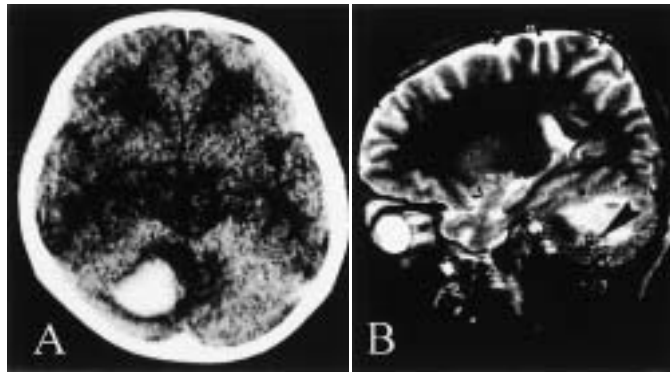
Cranial CT (A: axial image) and MR image (B: sagittal image SE4000/100) revealed a 4×3 cm hemorrhage in the right cerebellar hemisphere. Flow void represented the nidus (▶).
